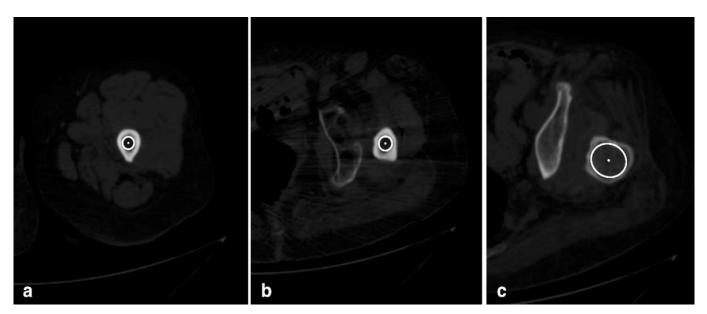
Axial CT images showing the plane of the isthmus (Ti) (a), DT-70 (b), and DT+35 (c) for the right hip of a 47-year-old woman.
